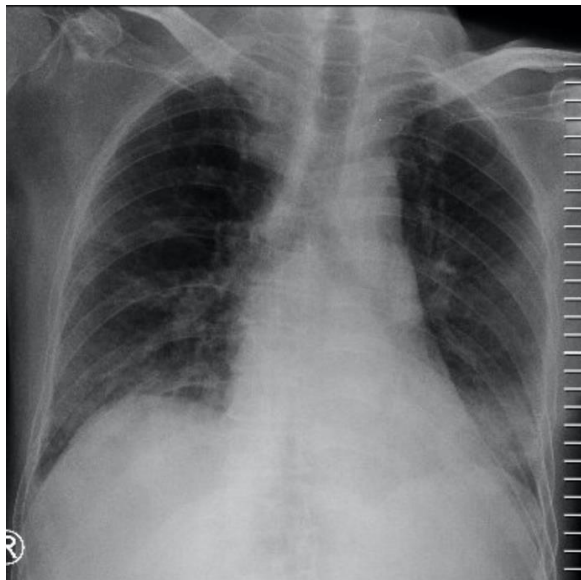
Chest X-Ray (1st Day)
